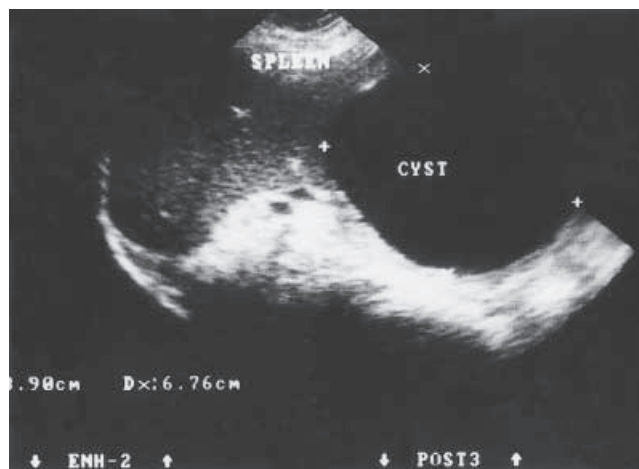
Ultrasonography showing a splenic hydatid cyst
